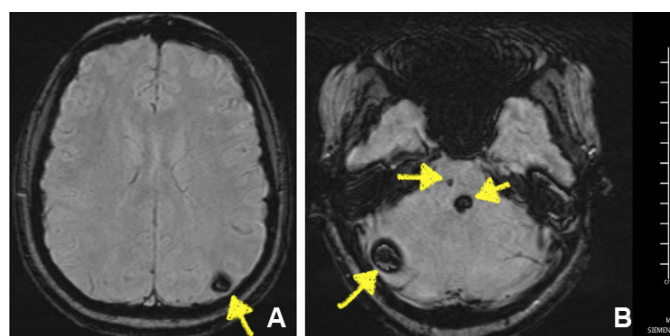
MRI susceptibility weighted images (SWI) showing the classical appearance of multiple cavernomas with hemorrhagic compositions (yellow arrows).
